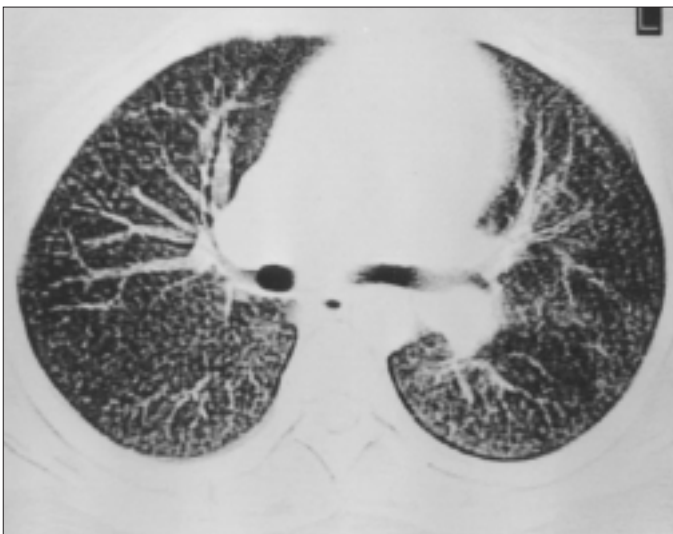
Thorax CT of the case 2 before therapy
